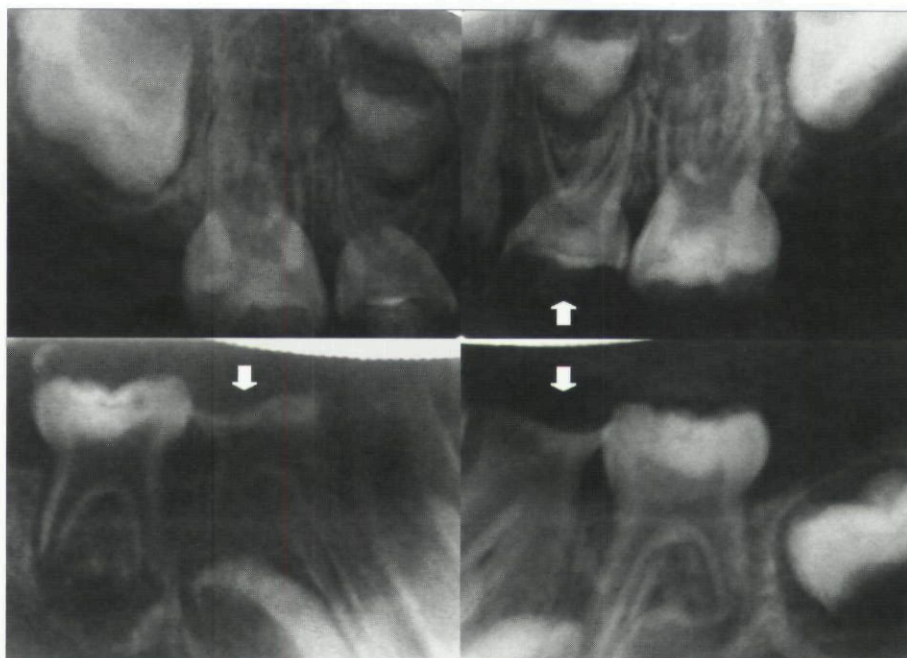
Intraoral radiograph examinations showing the flat occlusal surfaces of first primary molars.
